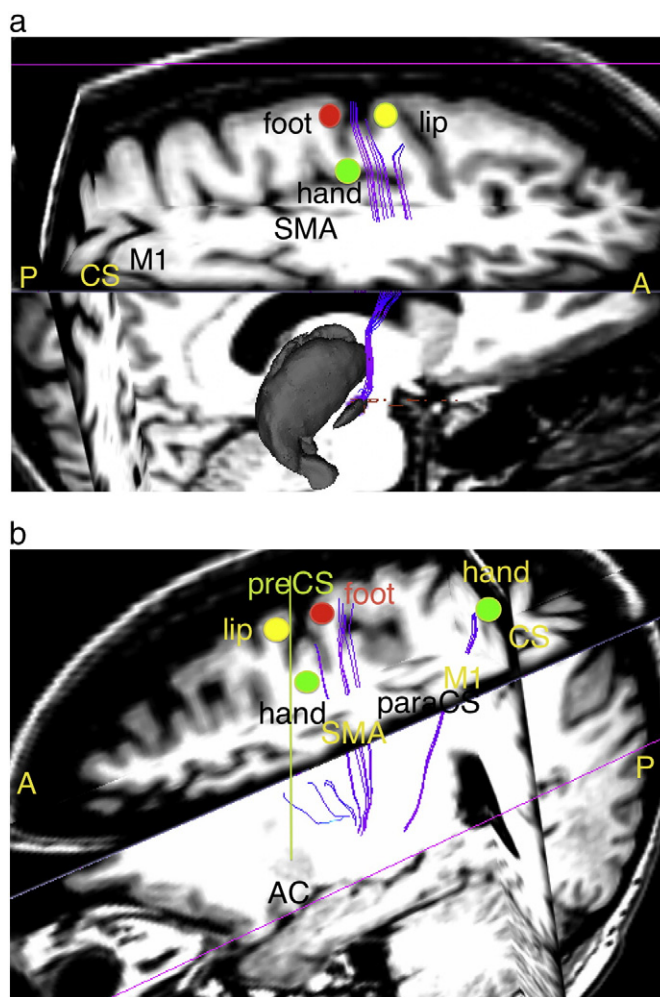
Sagittal MRI with overlay partial axial and coronal parts for Pat #7 a) left; b) right side. In a) also anatomical images of the thalamus and STN from SPL and 3D atlas [17,18] were overlaid. Tractography was generated from contact 1 on the basis of MRI/DTI images as described in details [16]. CS - central sulcus, para-CS - paracentral sulcus; pre-CS - precentral sulcus, AC - anterior commissure, A - anterior, P-posterior, M1 - primary motor cortex, SMA - supplementary motor cortex; hand, foot and lip - approximate position of M1 or SMA somatotopic projections.
